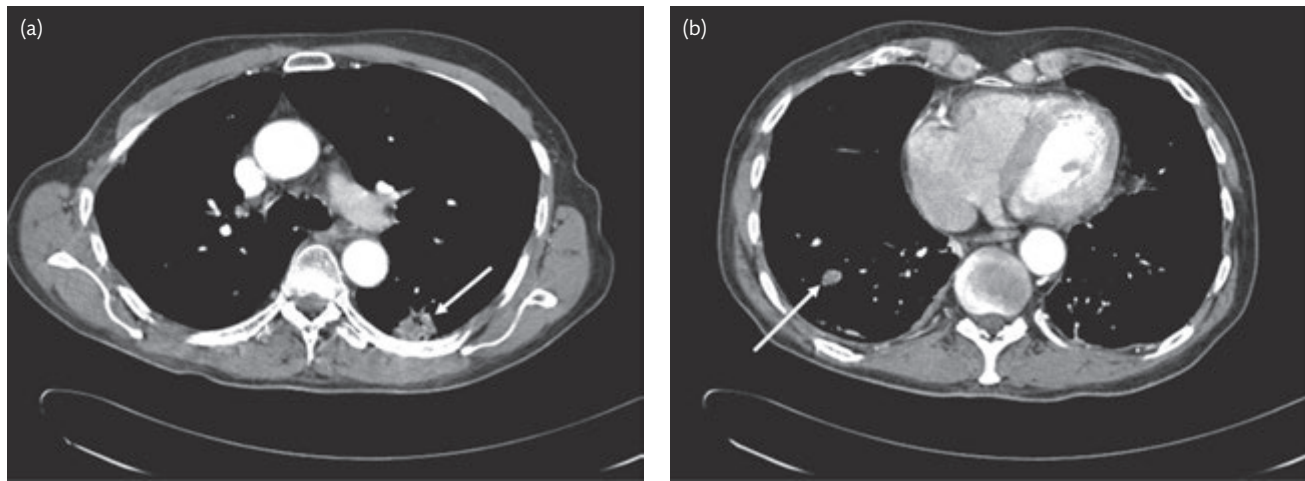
CT of a patient with lymphomatoid granulomatosis showing (a) a cavitating mass in the left lower lobe (arrow) and (b) a further mass in the right lower lobe (arrow).
